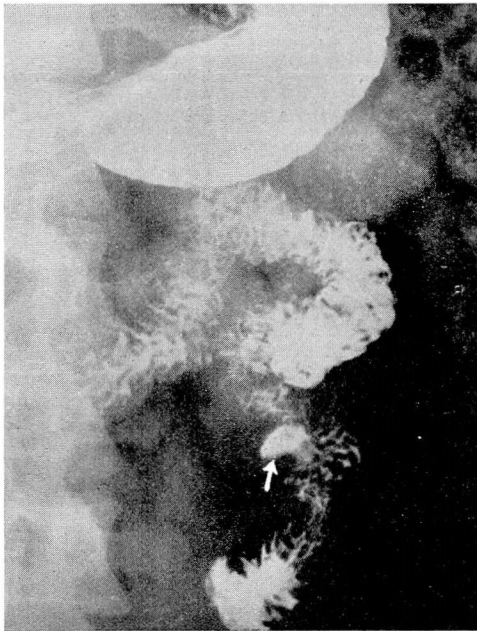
Leiomyosarcoma of the jejunum. Tumor intramural in origin but growth did not project into the lumen. Ulcer crater and slight ulceration of mucosal pattern are only roentgenogenic sign of this tumor; measurement 6 x 4 x 3 cm.
